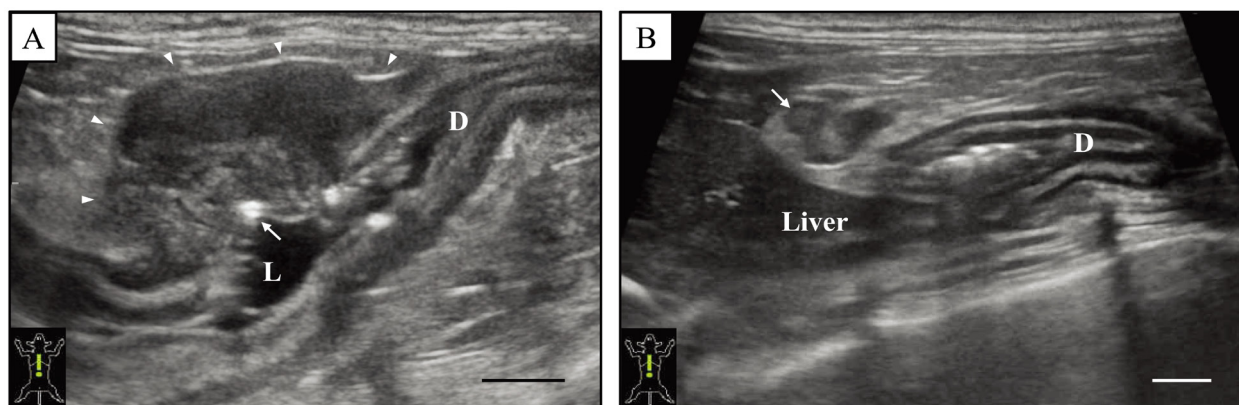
Sagittal ultrasonography of the duodenal mass. A: Abdominal ultrasonography revealed a mass measuring 11.6×16.9 mm in the area of the descending duodenum (arrowheads). The mass, observed as heterogenous echogenicity on the intestinal wall, protruded toward the serosa. The normal five-layer structure of the intestinal wall was altered at the site of the mass. The surface of the mucosa was irregularly delineated and either thin or absent on the mass. A concave mucosal defect was present at the center of the mass (arrow). No sign of luminal obstruction was observed. D: duodenum, L: lumen of the duodenum. Bar=5 mm. B: Mild enlargement of the pancreaticoduodenal lymph node measuring 8.1×6.2 mm was observed (arrow). D: duodenum, Bar=5 mm.
